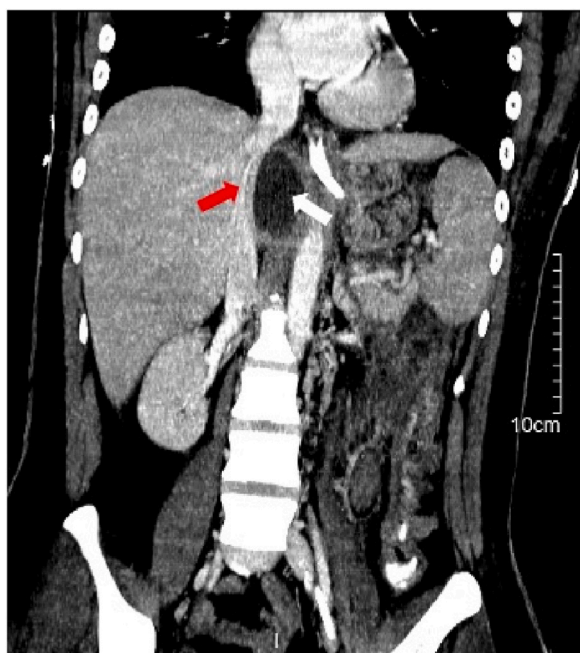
Coronal abdominal CT with contrast demonstrating a cystic mass (white arrow) compressing adjacent suprahepatic IVC (red arrow). Abbreviation: IVC: inferior vena cava.
